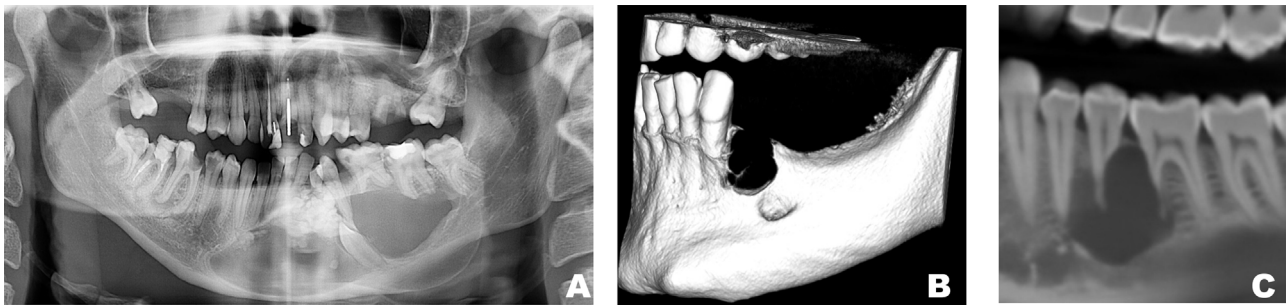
Radiographic features of “ameloblastomatous-lined” cysts. (A) Panoramic view showing an extensive unilocular radiolucency involving the body of the mandible and including an impacted tooth and calcifications. The final diagnosis was a calcifying odontogenic cyst associated with a complex odontoma. (B) 3D reconstruction of a CBCT showing a pseudo-unilocular radiolucency involving alveolar bone after the extraction of tooth 34. The final diagnosis was an unicystic ameloblastoma. (C) Sagittal section of a CBCT showing an unilocular radiolucency with root resorption of teeth 35 and 36. The final diagnosis was an unicystic ameloblastoma.
